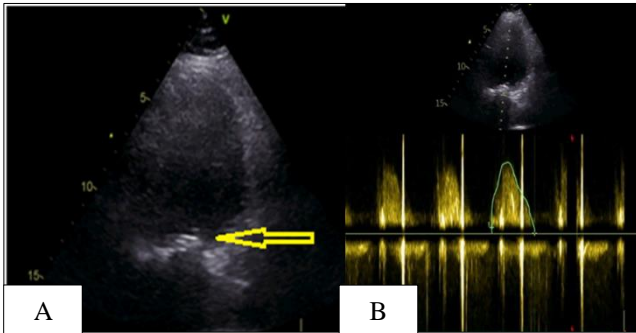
A) Transthoracic echocardiogram showing a soft thrombus (Yellow arrow) on the mechanical valve with restricted mobility of the leaflets, B) continuous wave Doppler recording across prosthetic mitral valve (mean gradient 15mmHg).
